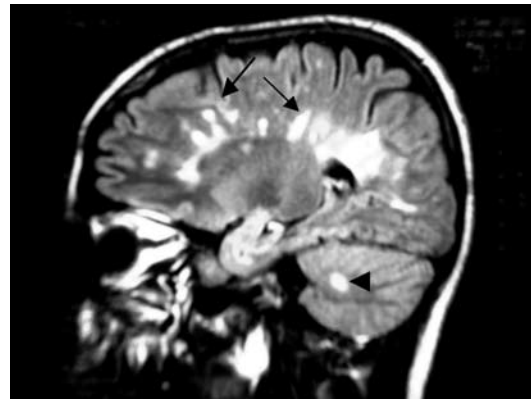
Sagittal view of brain MRI (FLAIR) showing multiple bright lesions in the corpus callosum (arrows) and one lesion in the cerebellum (arrowheads).
